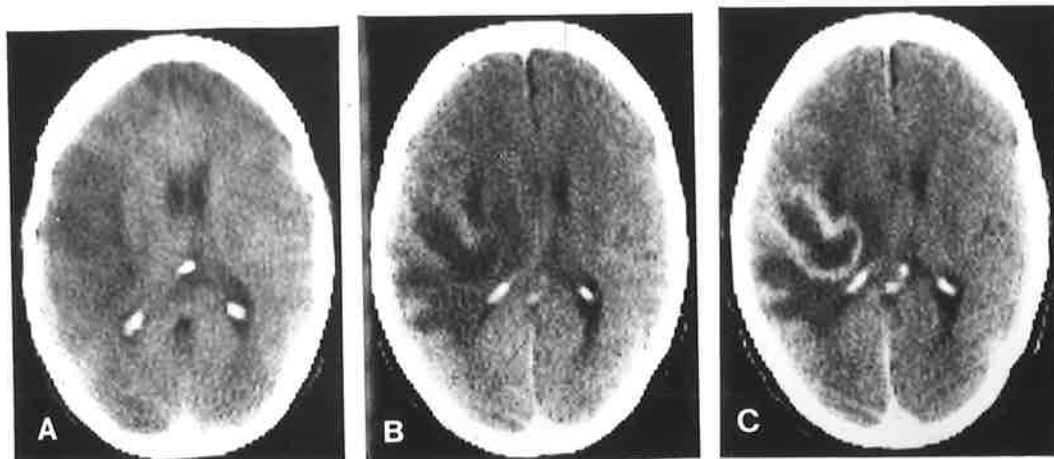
A. Enhanced CT scan of a patient with a low grade astrocytoma of temporal lobe. Extensive area of hypodensity but no enhancement because new tumour capillaries resemble normal cerebral capillaries with maintenance of BBB. B,C. Glioblastoma multiforme. B, plain study. Extensive vasogenic oedema. C, after contrast. Intense enhancement of tumour due to disturbance or even complete absence of BBB.
